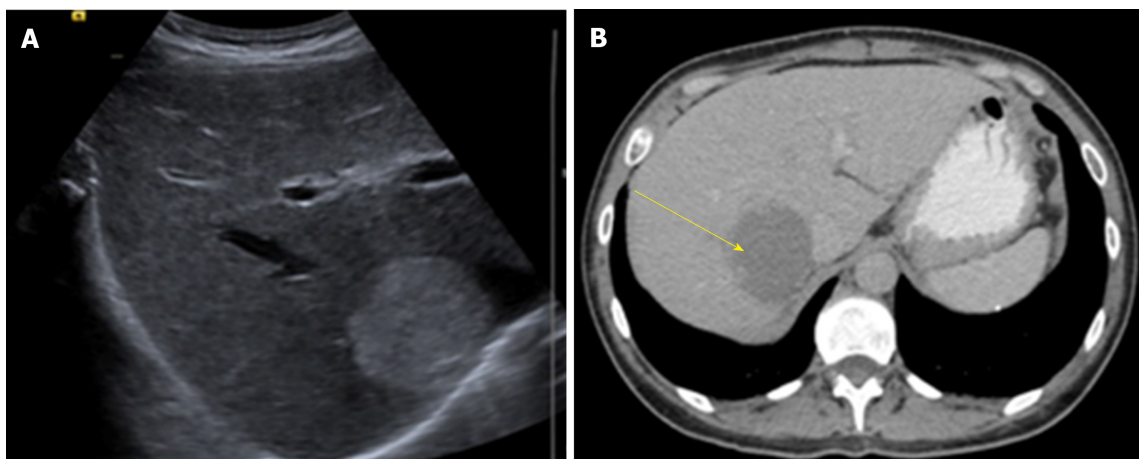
Liver ultrasound and computed tomography abdomen with contrast of a patient with hepatic hemangioma (55 mm × 46 mm). A: Image of ultrasound; B: Image of computed tomography.
